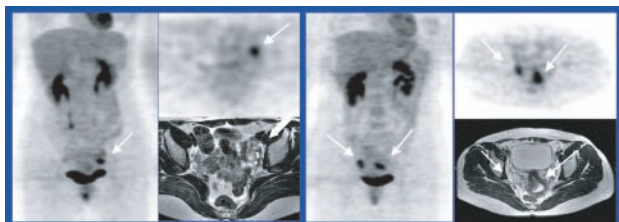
Left: Focal ^{18}F -FDG uptake was shown in the normal left ovary of a 37-year-old woman in ovulation phase. Right: Foci of intense ^{18}F -FDG uptake were observed in the normal ovary and uterine endometrium of a 42-year-old woman in the early luteal phase.
